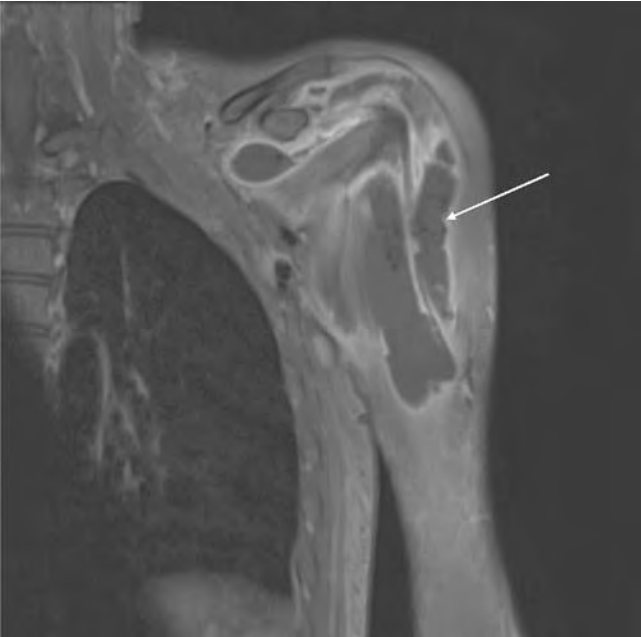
Magnetic resonance image (T1-fat sat post-gadolinium) of the left arm confirming the presence of a complex intramuscular collection of the deltoid muscle (arrow) with no evidence for osteomyelitis in pyomyositis patient 1
